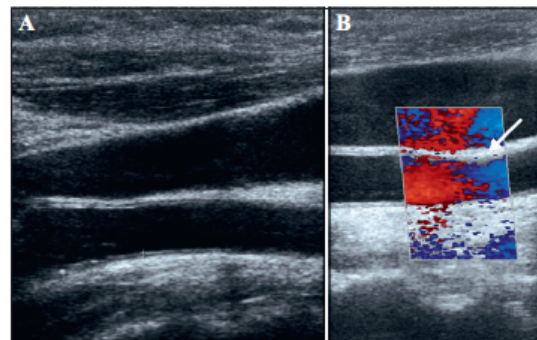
Doppler ultrasound examination. A) The two bright echogenic lines in the arterial wall were identified as the intima and media lines. The IMT was measured as the distance from the main edge of the lumen-intima interface to the media-adventitia interface of the carotids. B) Atheroma plaque in a patient with psoriasis (arrow).
